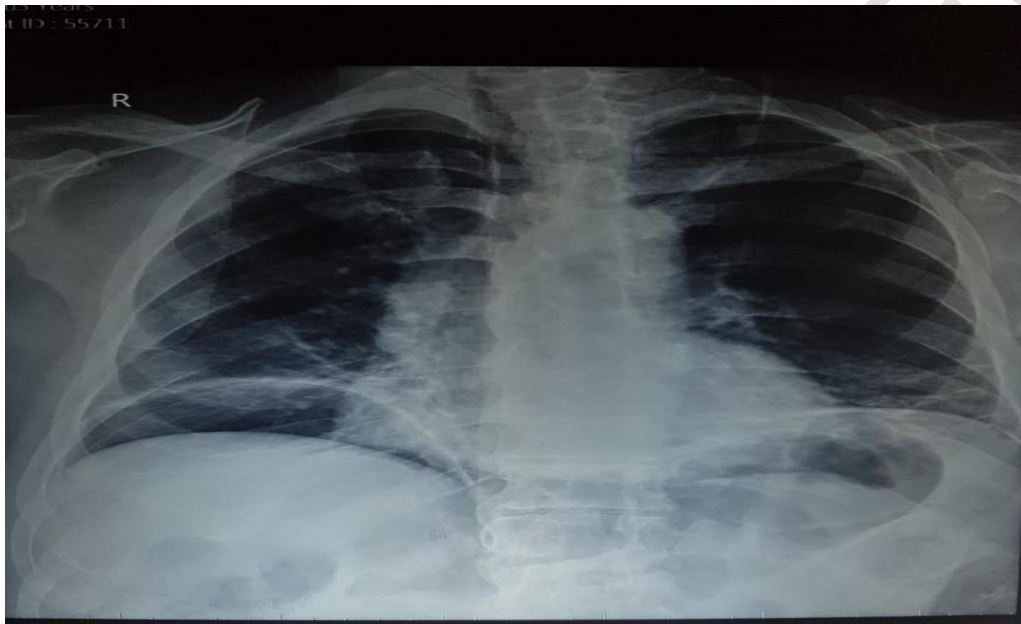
X-ray erect abdomen showing free gas under the diaphragm.
